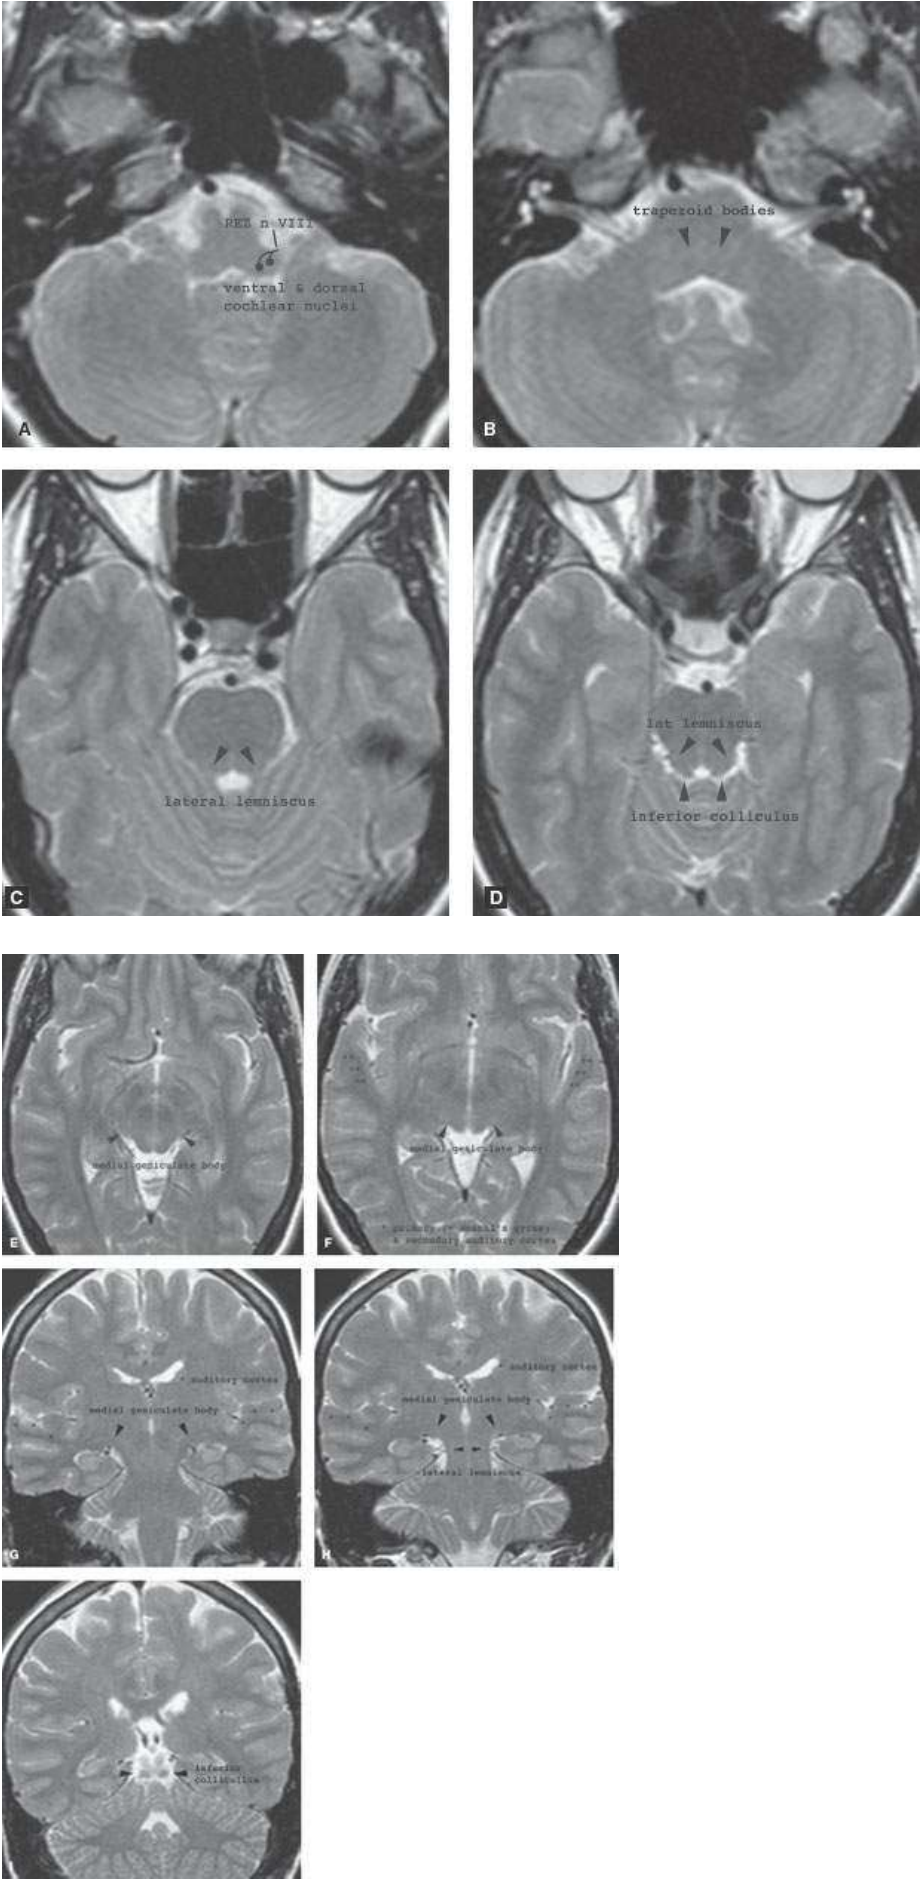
Normal anatomy of the central auditory pathway shown on axial (A–F) and coronal (G–I) T2W MR images. Afferent pathways of the central auditory system involve the cochlear nuclei, olivary nuclei, lateral lemniscus, inferior colliculus, medial geniculate body, and auditory cortex.
